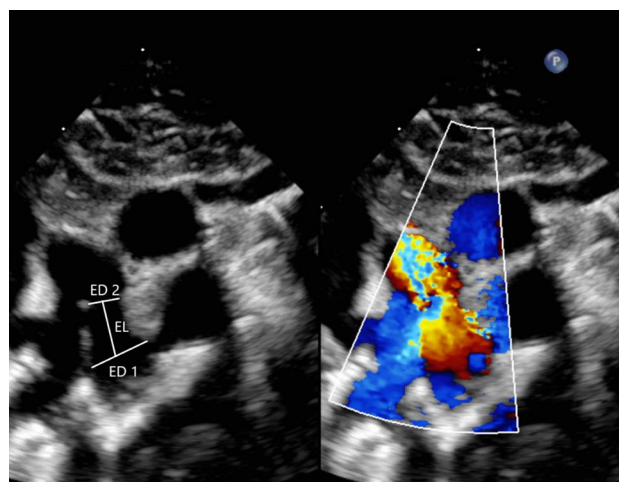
Echocardiography images with and without color Doppler demonstrate measuring the patent ductus arteriosus (PDA) dimensions. ED1 echocardiography aortic end (ampulla) dimension. ED2 echocardiographic narrowest end dimension. EL Echocardiography length of the PDA
